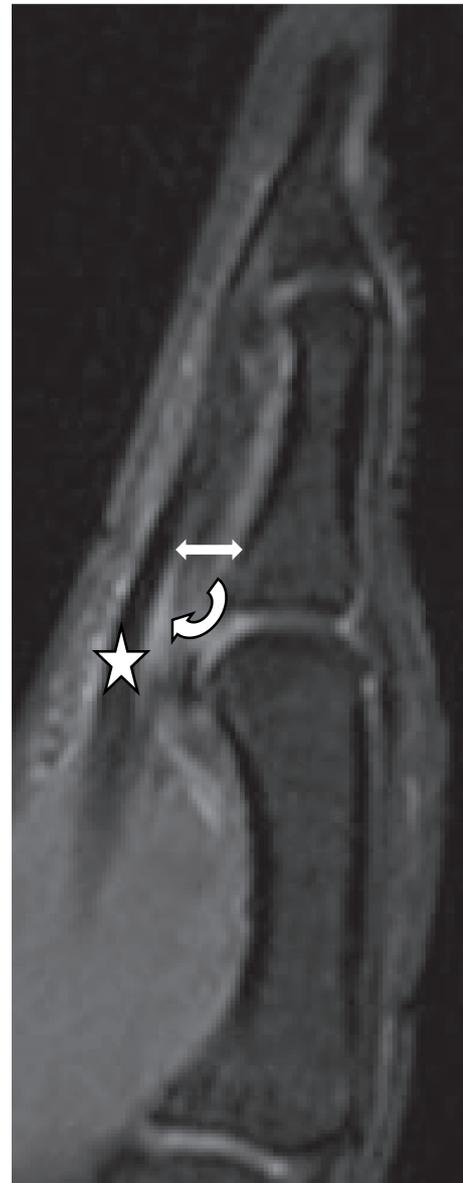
Same patient. Sagittal fat saturated proton density MRI demonstrates volar displacement (“bowstringing”) (double arrow) of the flexor pollicis longus tendon (star) with associated tenosynovitis (curved arrow).
